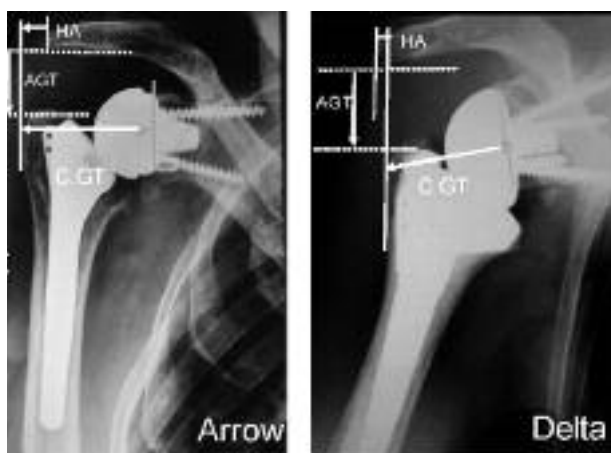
Antero-posterior radiograph of the Arrow and Delta prostheses. HA : Distance between acromion and humerus ; AGT : distance between acromion and greater tuberosity ; CGT : distance between center of rotation and greater tuberosity.
